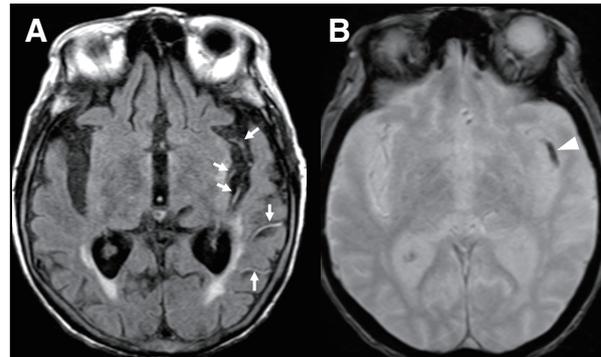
FHVx on FLAIR imaging in the left MCA territory (arrows, A). The SVS on T2*-weighted imaging of the M2 segment of the left MCA (arrowhead, B). FHVx: hyperintense vessels; MCA: middle cerebral artery; SVS: susceptibility vessel sign
